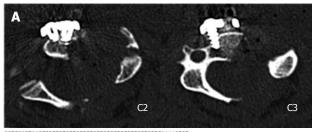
Postoperative axial (A) and sagittal (B) reconstructed computed tomography scans of the cervical spine shows the oblique corpectomies and a fixation with an anterior plating C2-C4.
